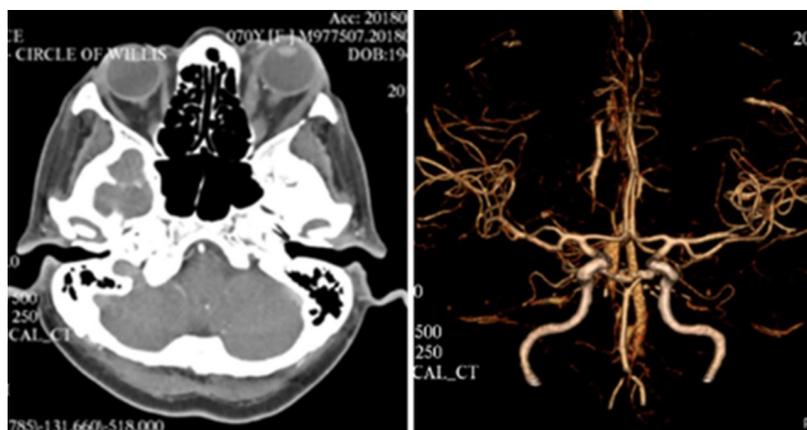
CT angiogram of brain showing mild proptosis of left globe, relatively enlarged left medial rectus with no tendon involvement and normal superior ophthalmic vein. Normal cavernous sinuses.
